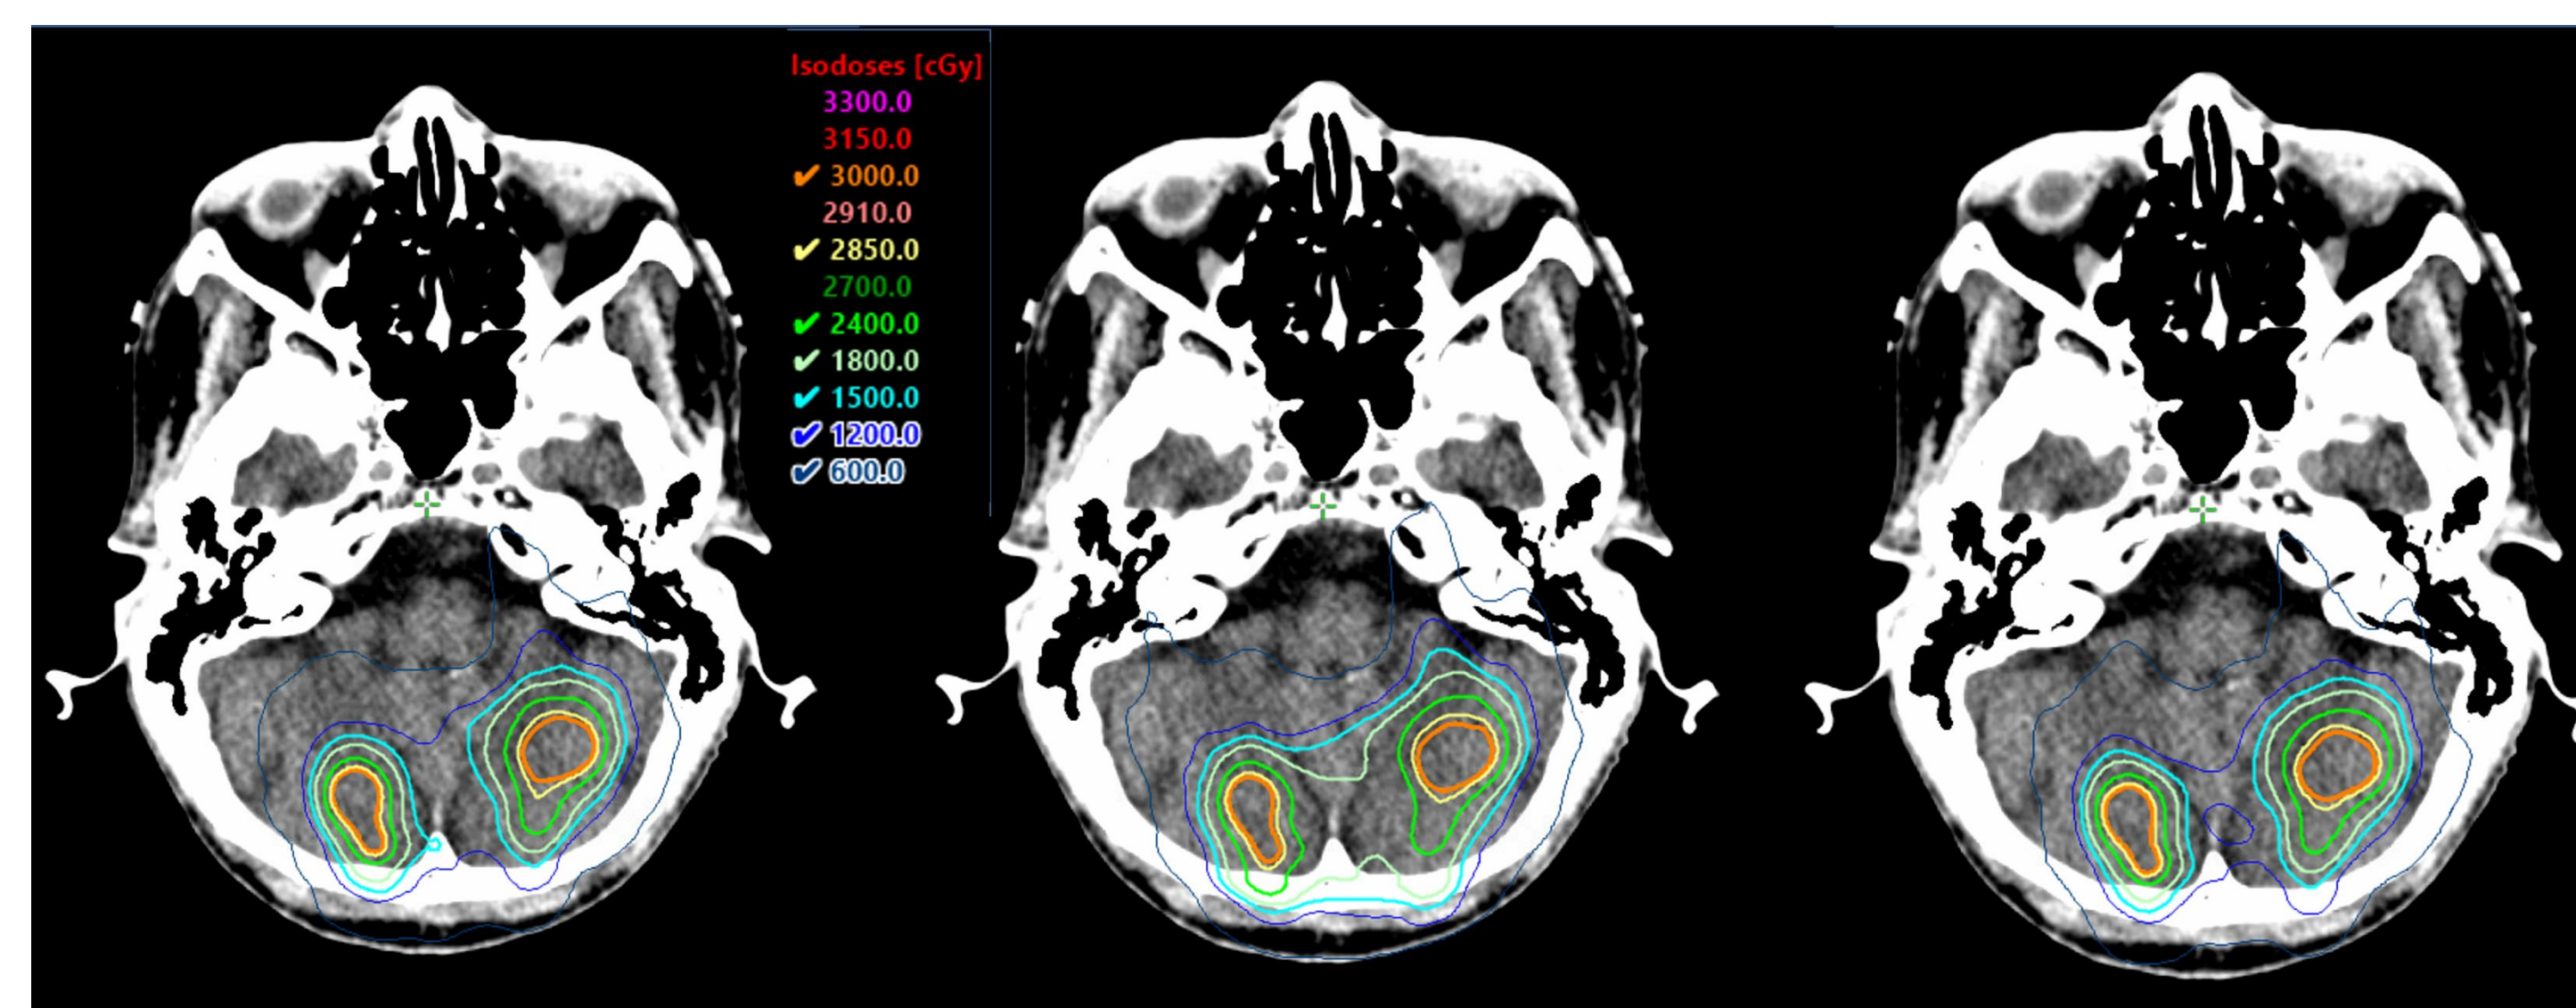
Axial CT images demonstrating intermediate dose bridging between adjacent lesions in the posterior fossa for (A) manual rings optimization, (B) Normal Tissue Objective (NTO) optimization, and (C) manual rings and NTO both utilized during optimization.
